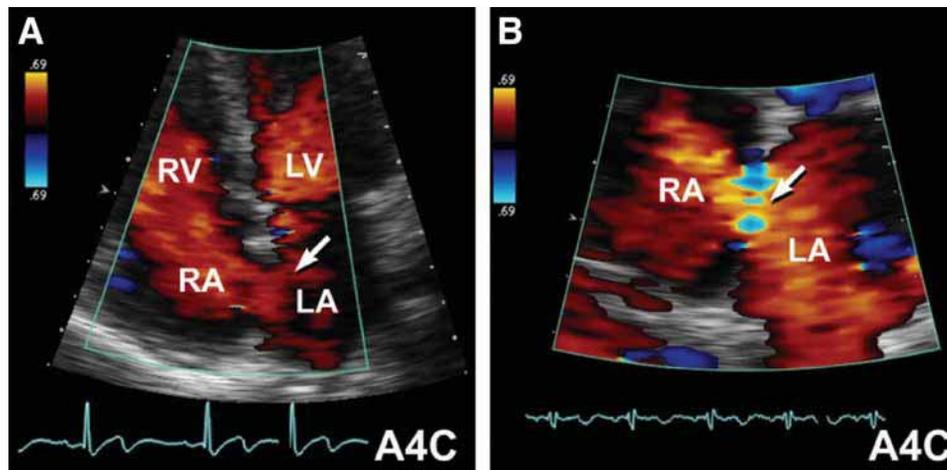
Transthoracic apical four-chamber view (A4C) with color flow Doppler interrogation of the interatrial septum shows left-to-right shunt via a secundum defect.
